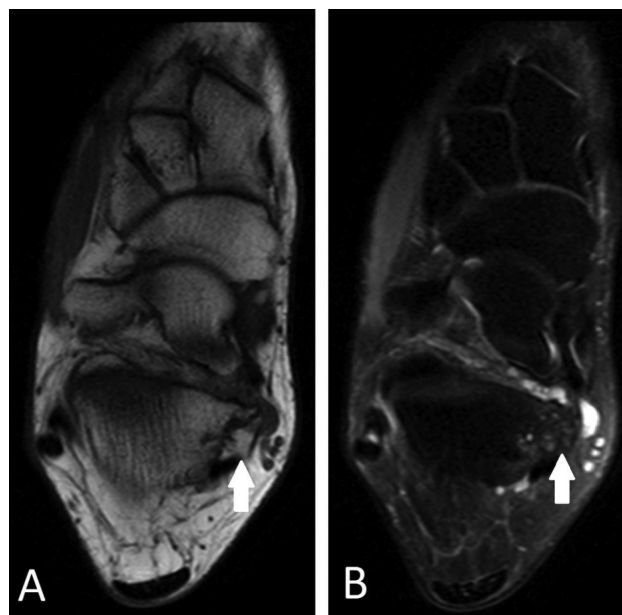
MRI of the right ankle in the axial section in the T1 sequence in A and the T2 FAT SAT sequence in B showing a talocalcaneal coalition with *Os sustentaculum* (white arrows).
